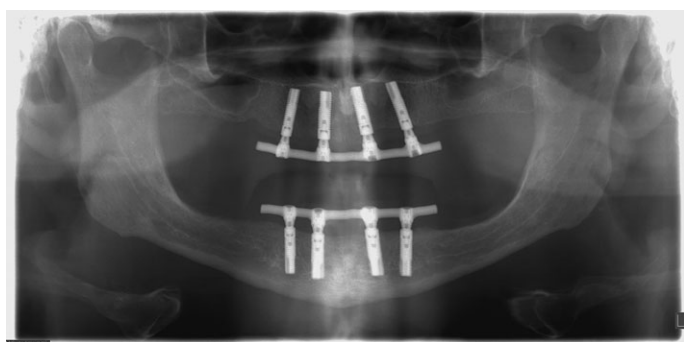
Five-year panoramic radiograph of a patient with four implants connected with a bar in the maxillary anterior region.
